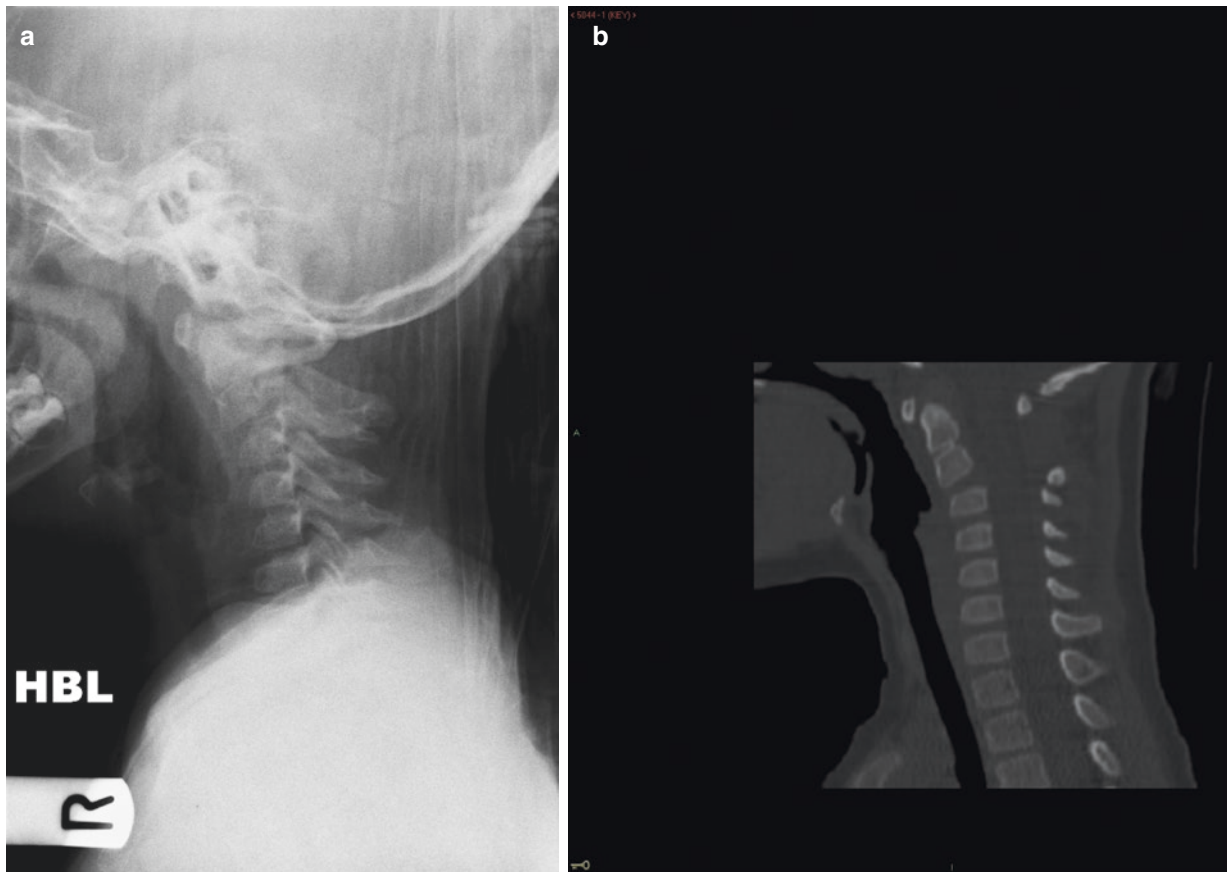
Hangman's fracture. (a) Lateral cervical spine radiograph demonstrates anterior subluxation of C2 on C3, pars fracture and increased distance between the spinous processes of C1 and C2. (b)
